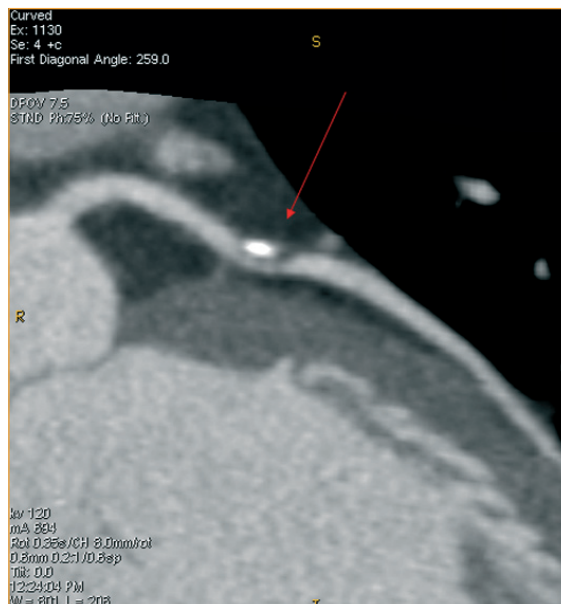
Severe coronary stenosis (arrow) by cardiac CT with mixed calcified (bright) and non-calcified (darker) plaque in the mid LAD of a 58-year-old smoker with ongoing chest tightness despite a normal 12-minute exercise stress test. He went on to have a successful stenting of the LAD and remains pain-free at follow-up.
